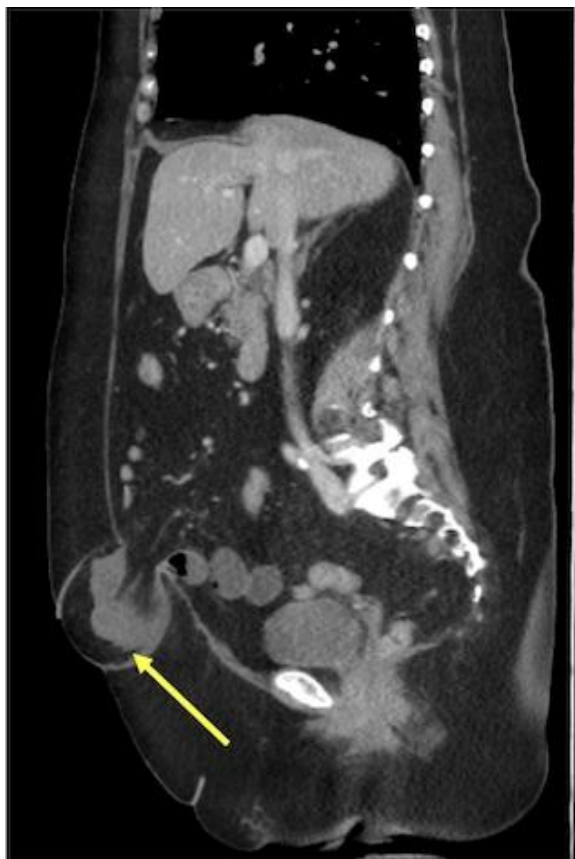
CT scan coronal view with the strangulated bowel (yellow arrow).
